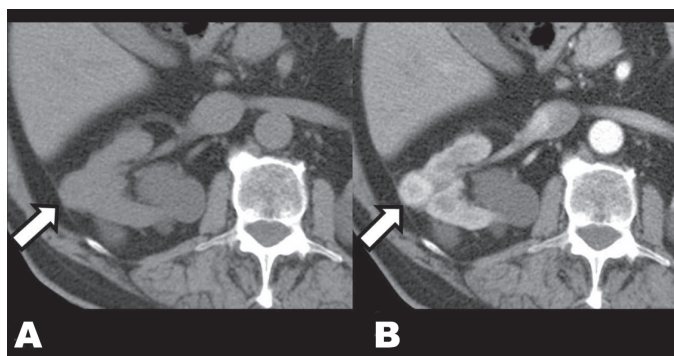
(A) Computed tomography scan showing without intravenous contrast: exophytic isodense nodule compared to the rest of the renal parenchyma (white arrow), (B) Computed tomography scan in arterial phase after the administration of intravenous contrast: early enhancement predominates at the periphery of the nodule (white arrow).
